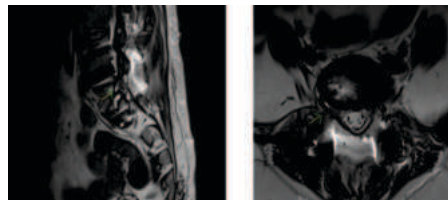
MRI showing the Conjoined nerve root: Sagittal and Axial section
